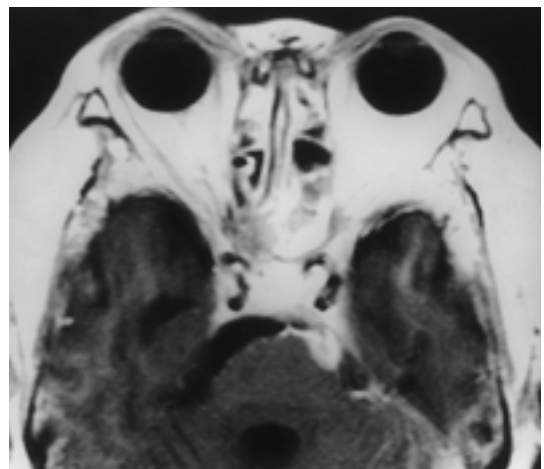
Case 5 (65/F) with left septic cavernous sinus thrombosis. Enhanced axial T1-weighted image shows enhancement on anterior portion of the pons and adjacent meninx.
